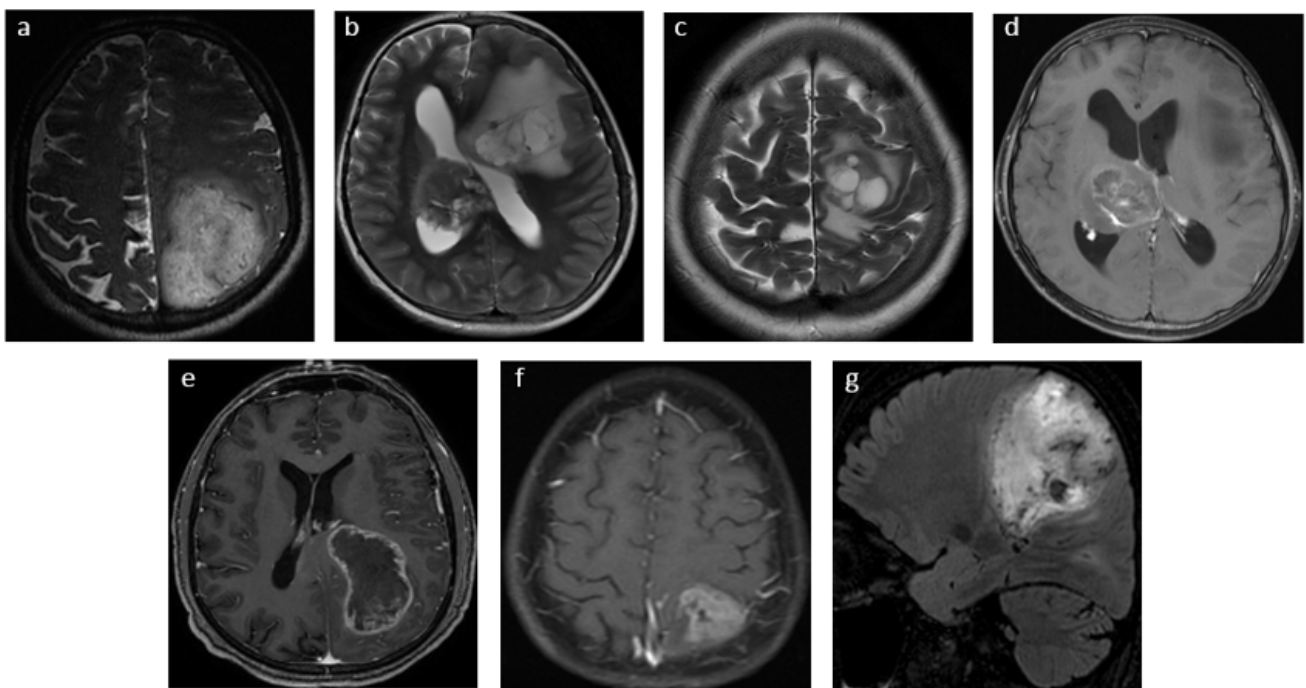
MRI features of grade III ODG patients with of $1p/19q$ co-deletion. Imaging findings showing: (a) indistinct borders on T_1W , (b) GRE sequence with paramagnetic susceptibility and calcification and, (c-d) mixed signal intensities on T_1W and T_2W . GRE, gradient echo; ODG, oligodendroglioma.
